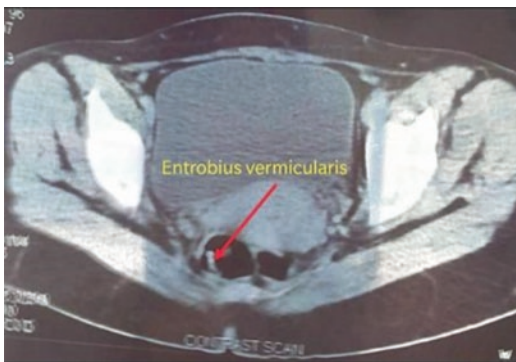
CT image (in non-pregnant) showing *Enterobius vermicularis* mimicking as a foreign body
